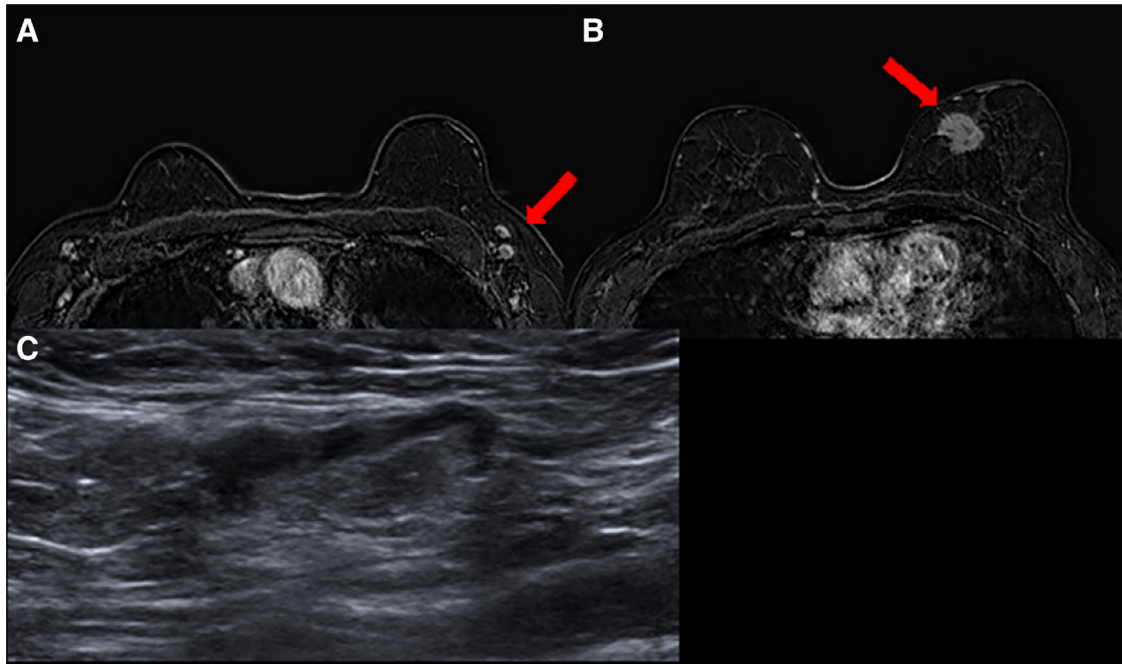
MRI and sonographic characteristics of benign nodes. T1 fat-saturated magnetic resonance imaging 2 minutes after administration of contrast media (A) in a woman aged 68 years with a suspicious mass in the median-inner quadrant of the left breast (B, red arrow) showing bilateral enlarged nodes with central fatty hilum. (C): The targeted ultrasound demonstrated normal appearance of one of the nodes. A fine-needle aspiration was performed with a cytologic diagnosis: polymorphous lymphoid population, negative for malignant cells.
